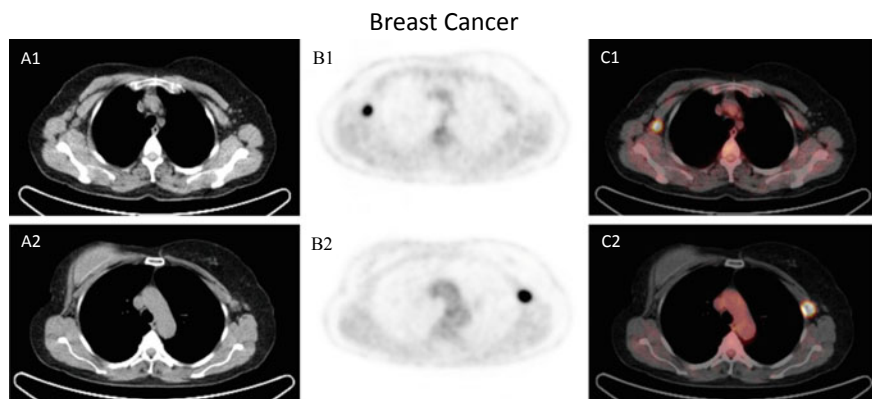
56-year old female patient with history of breast cancer of the right breast (initially TNM-classification pT1b pN0 L0 V0 R0 G3) after surgery and adjuvant radiation therapy, referred to FDG PET/CT for re-staging; clinically already suspicious focal tumour in the right axilla. FDG PET/CT confirmed FDG-positive lymph node metastasis in the right axilla; furthermore, PET/CT revealed an FDG-positive node contralateral in the left axilla, either contralateral primary tumour or further lymph node metastasis; (A1-2) CT-Scan, (B1-2) PET scan, (C1-2) PET/CT fused images
